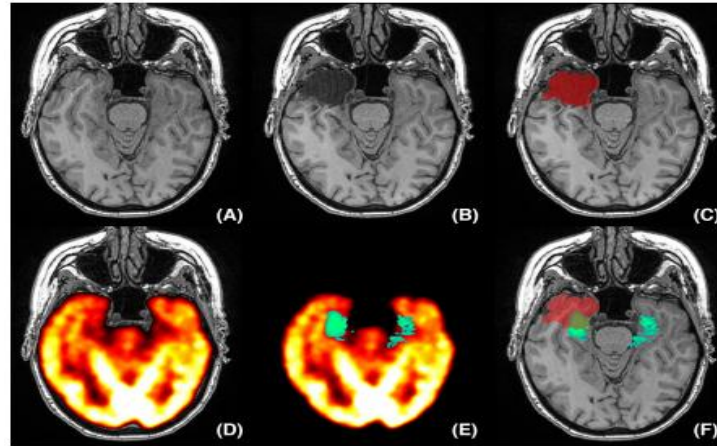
explains the epilepsy patient was analyzed before surgery by the use of (A) magnetic resonance imaging (MRI). (B) the post-op X-ray. (C) Segmented preoperative and postoperative MRIs were subtracted (red) to obtain the volume of the tissue that was removed. (D) MRI registration for FDG-PET (E) Comparison of hypometabolism to healthy controls (green). (F) Resection district overlay with hypometabolism (covered in green-light green), used to determine the amount of resected transient curve hypometabolism.
